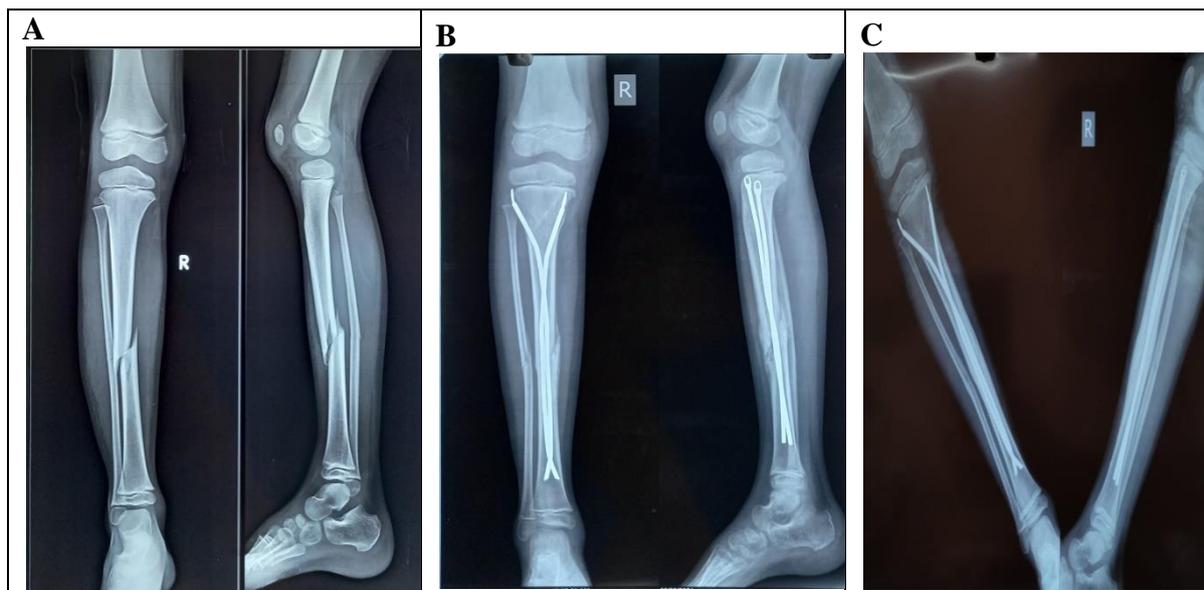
Radiograph for shaft tibia fracture of 9 year pediatric patient a) Pre operative b) Immediate post-operative c) Final follow up
